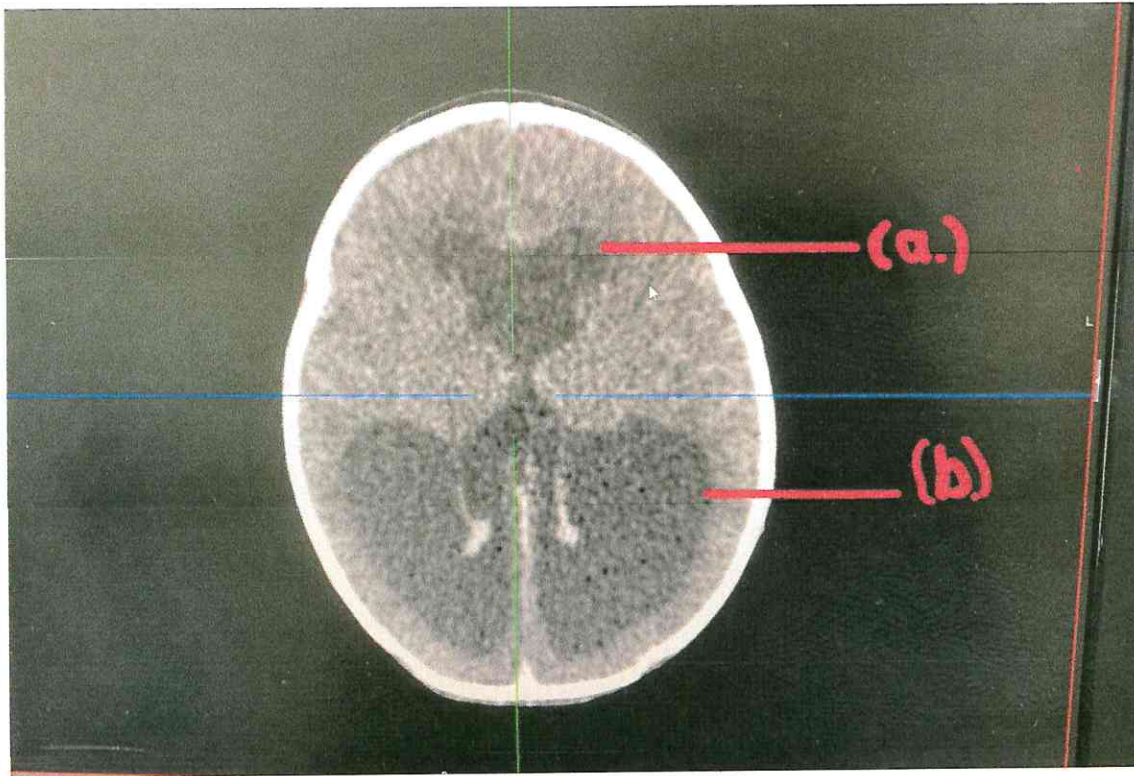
CT Brain depicting Colpocephaly (a)Smaller frontal lateral horns as compared to, (b) dilated occipital lateral horns depicted.(27).
